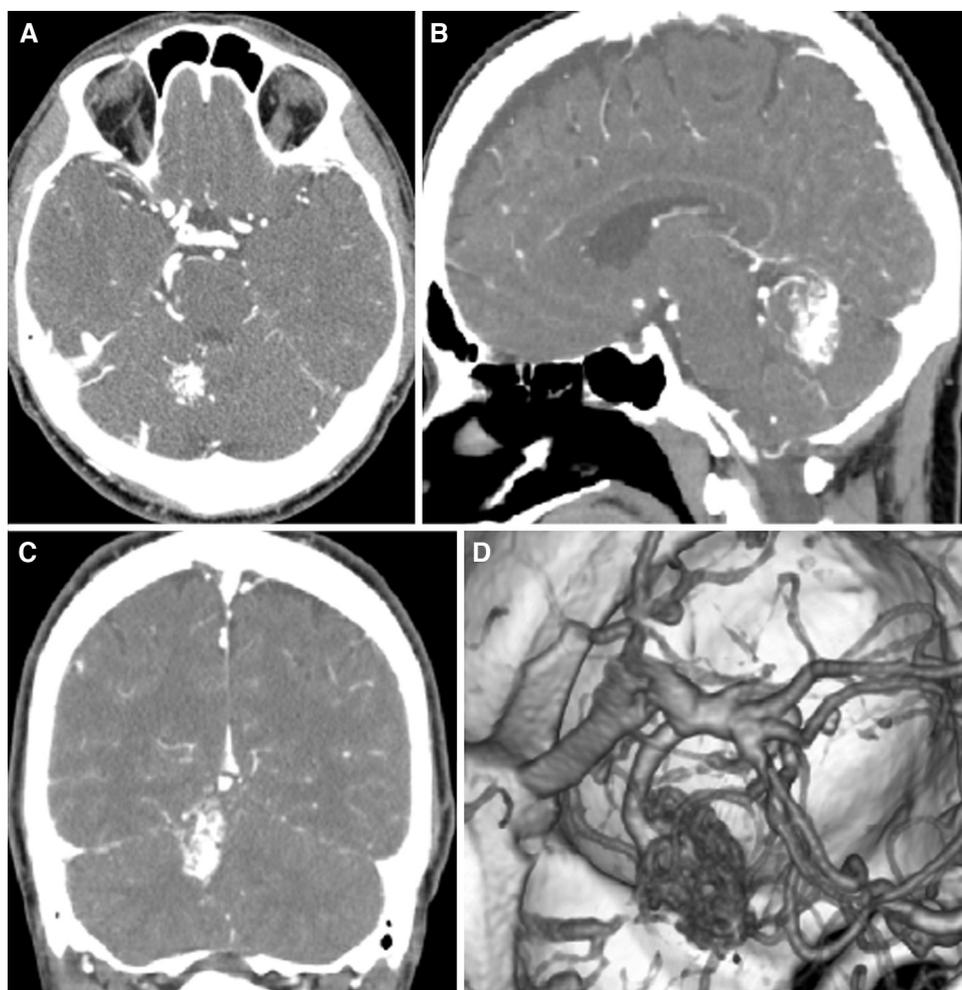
Preoperative images. Axial (A), sagittal (B), and coronal (C) CT angiograms showed a small (<3 cm) arteriovenous malformation of right cerebellar hemisphere. 3D volume-rendered CT (D) revealed a venous drainage through one dilated vein into the vein of Galen (anterolateral view).
